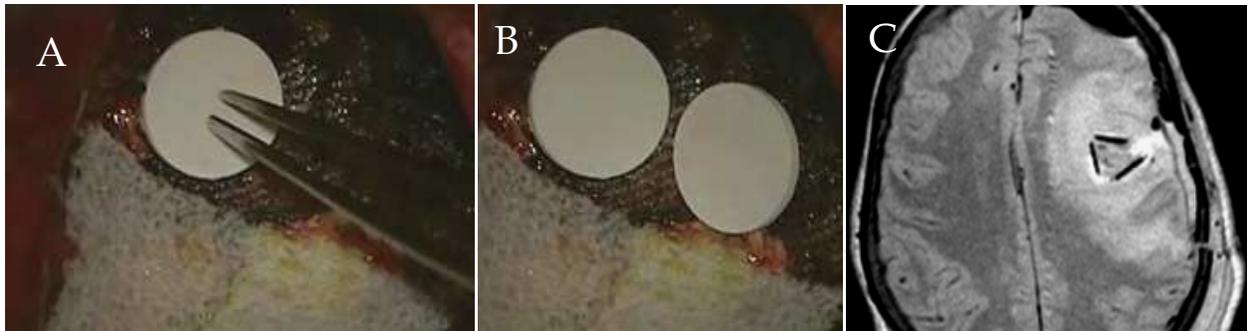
A shows the implantation of an Gliadel^R wafer. Two wafers in place (B) and a postoperative MRI scan showing 3 Gliadel^R wafers in situ.
